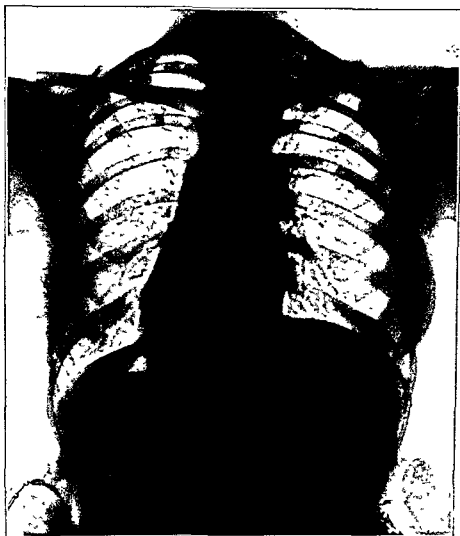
An x-ray of a young female (Case No 2) with an exudative tuberculosis in the apex of the right upper lobe. The annular shadow is very suggestive of cavity formation.
